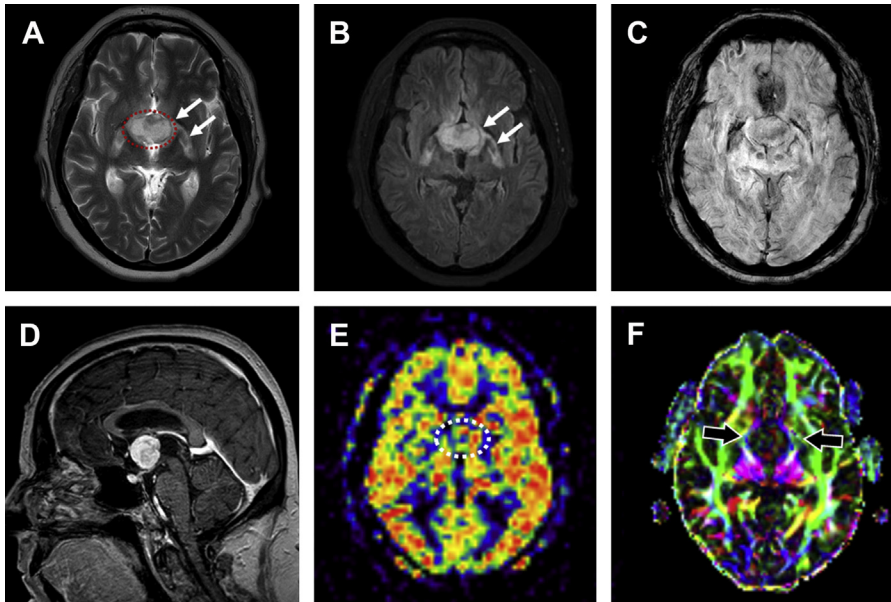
Multiparametric imaging of a chordoid glioma. The tumor has hyperintense signal on T2-weighted image (A, *red dashed circle*) and FLAIR (B). No blood products or calcification are found on SWI (C), and homogeneous contrast enhancement is seen on 3D T1 (D). The 2D pCASL scan is unremarkable, without evident increased perfusion (E). The overall morphology and the perfusion findings are consistent with a benign tumor. Although bilateral minimal edema is seen in the basal ganglia and diencephalon (*arrows in A, B*) the adjacent white matter tracts are displaced and no true destruction is found on the fractional anisotropy map (F, *arrows*).
